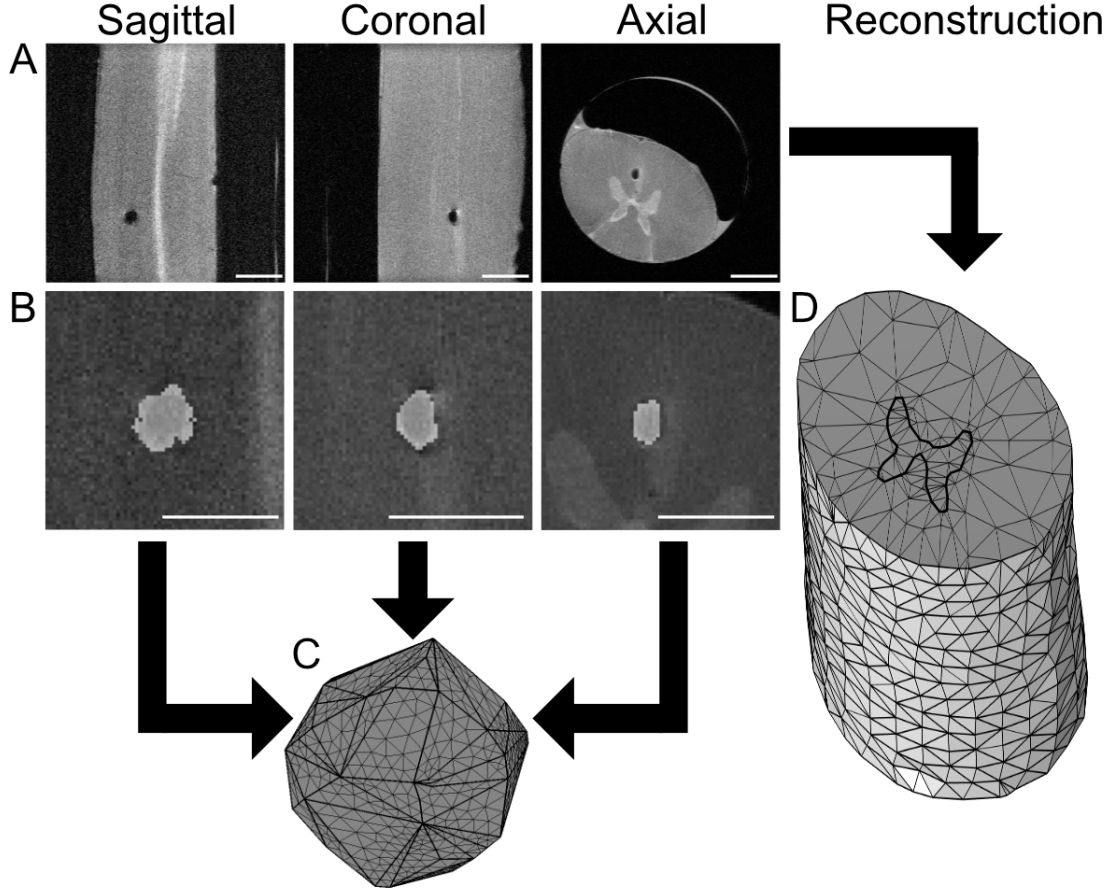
Reconstruction of the three-dimensional shape of a gas bubble from stacks of MR images in the three anatomical planes. (A) shows sample image slices of a bubble in the spinal cord in the sagittal, coronal, and axial planes, respectively. (B) shows the same slices after image processing to extract the bubble, and (C) shows the three-dimensional reconstruction of the bubble shape from the full stacks of these slices, and (D) shows the reconstruction of the surrounding spinal cord from an axial image stack. (A) scale bar = 5 mm (B) scale bar = 2.5 mm
